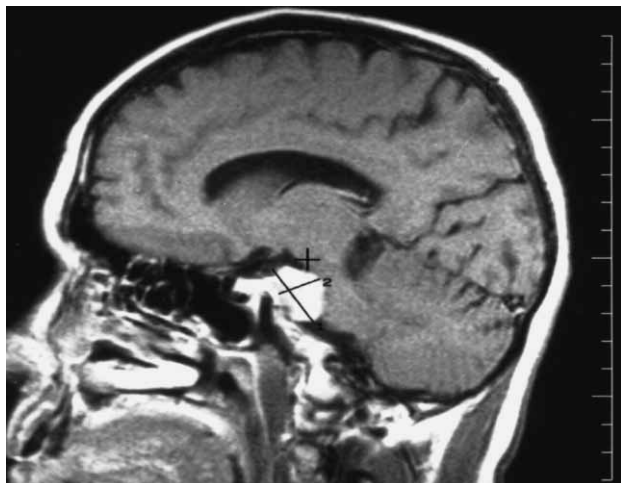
Preoperative magnetic resonance image (MRI) following contrast injection shows a large tumor with homogenous enhancement.
